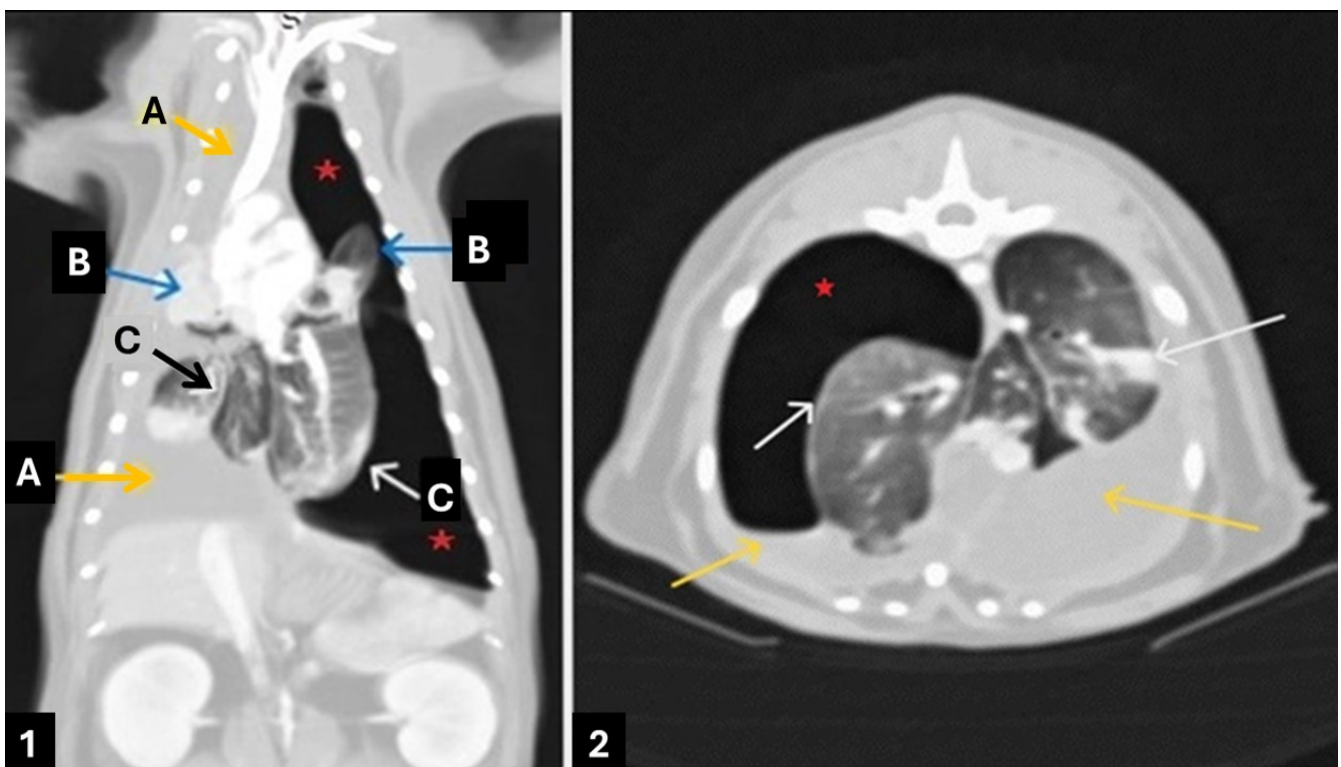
Computed Tomography Dorsal Plan (1) and Transversal Plan(2) Thorax Images. Pleural effusion - yellow arrows (A), lung atelectasis - blue arrows (B), visceral pleura density increase - white arrows (C), left sided pneumothorax red stars represented.
